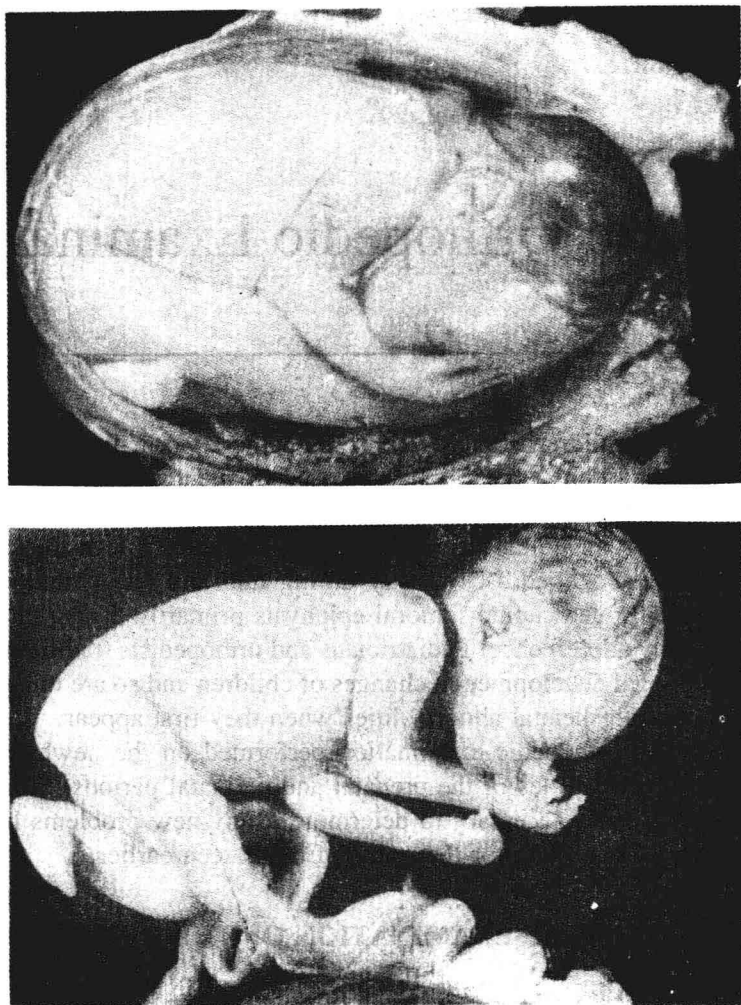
Fetus demonstrating the effect of intrauterine positioning during late trimester development. Top: Position *in utero*. Bottom: Residual limb attitudes after delivery. Reprinted with permission from *Medical Radiography and Photography*.
